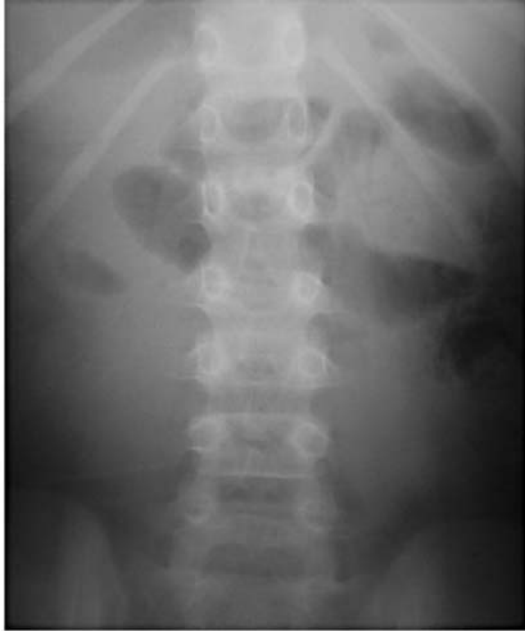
Widening of the interspinous space between the first and the second and between the second and the third lumbar vertebrae was noted on the thoracolumbar spine radiographs. No fracture was suspected on these films
